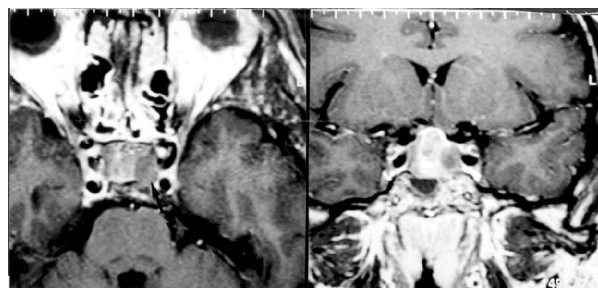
Axial and coronal magnetic resonance imaging sections of sellar region, showing pituitary non-homogeneous macroadenoma with suprasellar extension, showing left cavernous sinus involvement (arrow).
